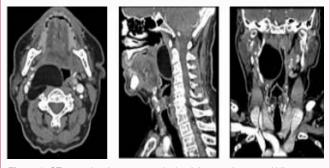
CT scan showing a septum in the right parapharyngeal hibernoma.
